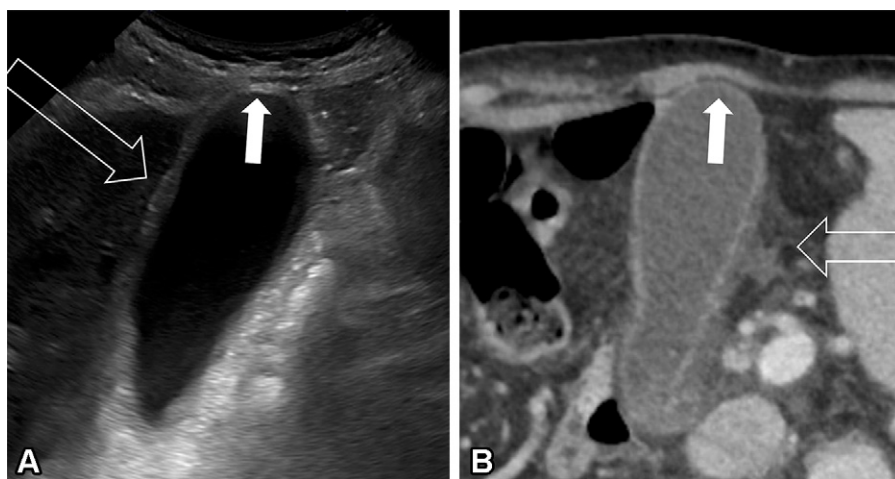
Acute cholecystitis in a 76-year-old man. (A) Gray-scale US image of the right upper quadrant (RUQ) shows the dilated gallbladder exerting mass effect on the anterior abdominal wall, bulging it outward (the tensile fundus sign) (solid arrow) so that it resists the transducer during assessment of the sonographic Murphy sign, with some area of wall thickening (open arrow). (B) Axial image from contrast-enhanced CT performed 2 hours before the US study shows the tensile fundus sign (solid arrow) and pericholecystic fat stranding (open arrow). While the gallbladder wall is mostly edematous, the area of contact with the abdominal wall is relatively thin.
